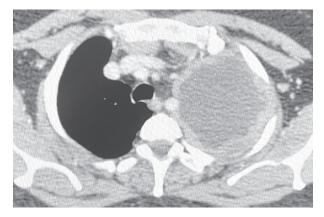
Computed tomogram of the chest showing left sided pleural effusion.
